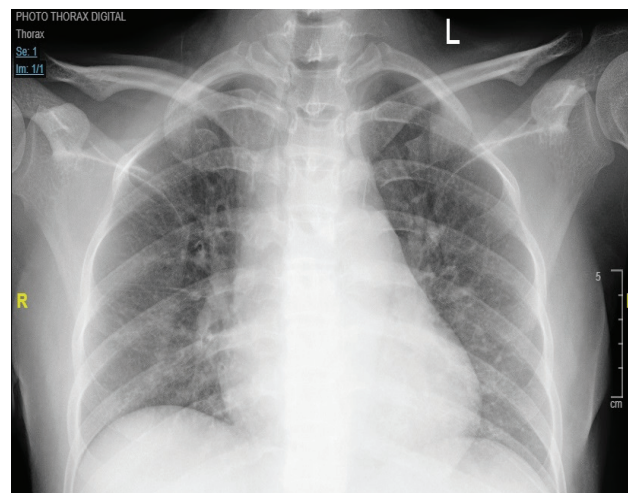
Chest X-ray (Patient No. 2)
